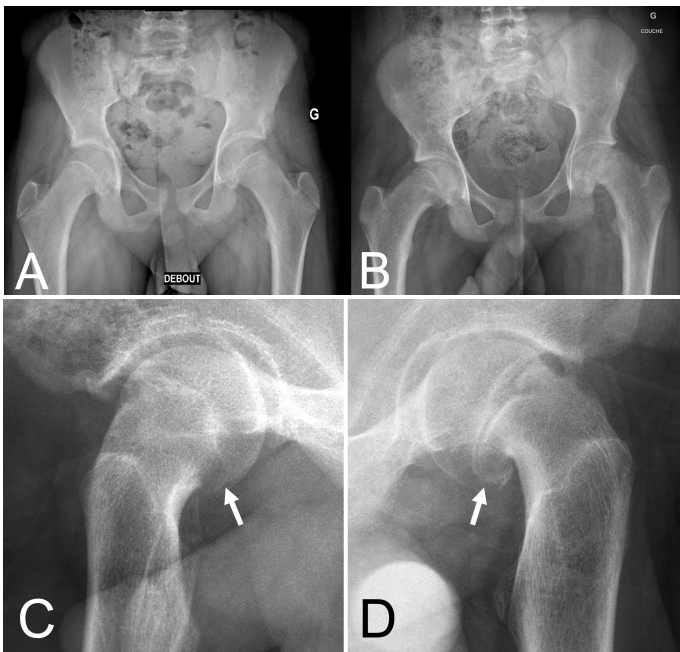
(A) antero-posterior radiograph of the pelvis one year before symptoms, which shows already at the right side signs of SCFE (external x-ray) (B) x-ray at time of acute on chronic symptoms. (C/D) Lauenstein view right and left with metaphyseal callus formation (arrows) and bilateral severe slipped epiphysis.
